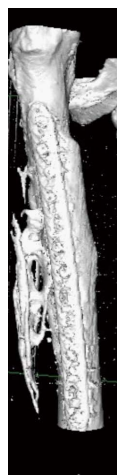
Heterotopic ossification in a 51-year-old male patient treated for femoral nonunion (3D CT reconstruction).
